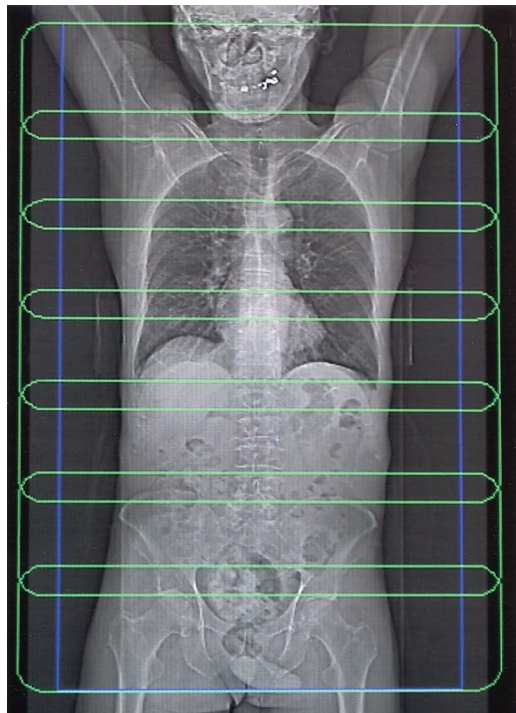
Typical scout image obtained during an FDG PET–CT study. The blue-purple rectangle represents CT coverage during the study, and each overlapping green rectangle represents PET coverage. Six to seven bed positions are required for PET coverage of the neck, chest, abdomen, and pelvis.
